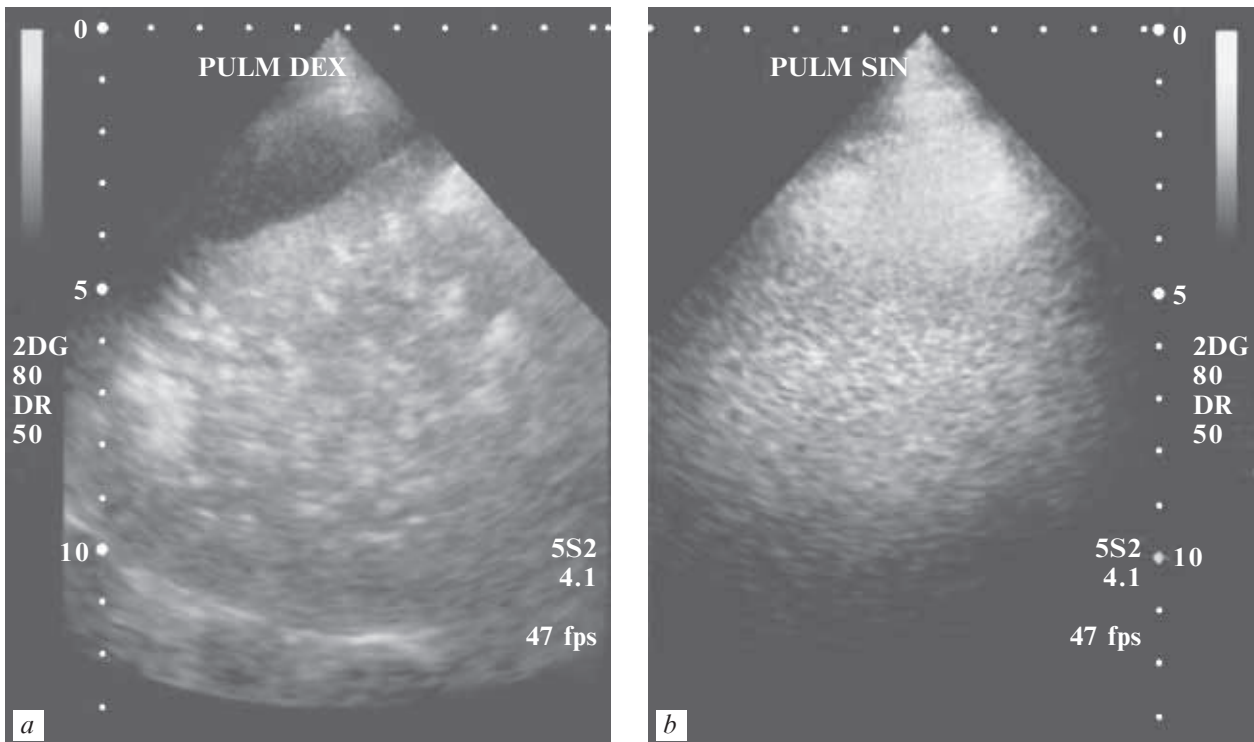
Ultrasound picture at bacterial lung destruction (infiltrative form) (a), healthy lung (b)
